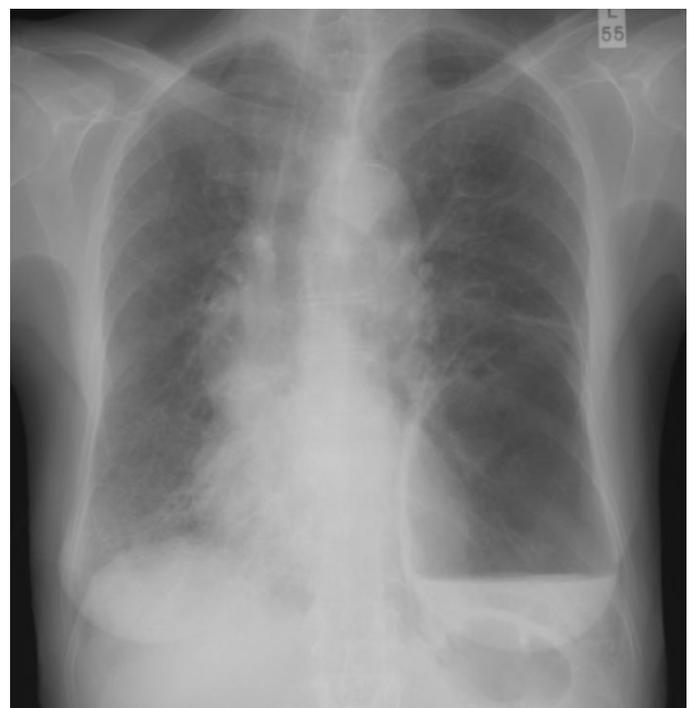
80 year old female with chronic pulmonary aspergillosis. Plain chest radiograph June 2004 after complete lysis of aspergilloma. Increasing fibrotic changes are seen in both lungs. The large cavity, with an air-fluid level, is seen at the left base.
